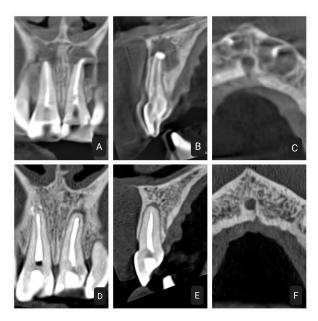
CBCT images of teeth 1.1 and 2.1: (A–C) Coronal, sagittal, and axial pre-treatment images show an osteolytic lesion measuring $11 \times 10 \times 8$ mm, resulting in expansion and fenestration of the vestibular table and (D–F) coronal, sagittal, and axial post-treatment images, which evidence significant bone regeneration in the affected area.
